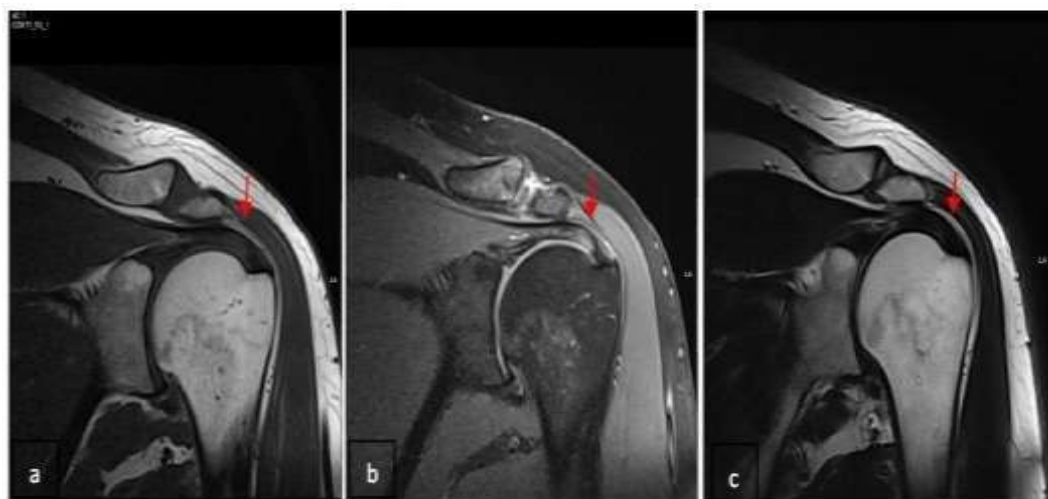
MRI (a) T1 coronal, (b) PD with fat suppression, (c) T2 WI shows abnormal intermediate signal of supraspinatus tendon in all sequences with no disruption of its fibers denoting tendinopathy, and shows osteoarthritis changes of acromioclavicular joint.
